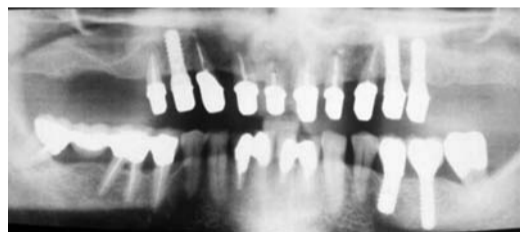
Orthopantomograph taken at the completion of the perioimplant- prosthodontic treatment
